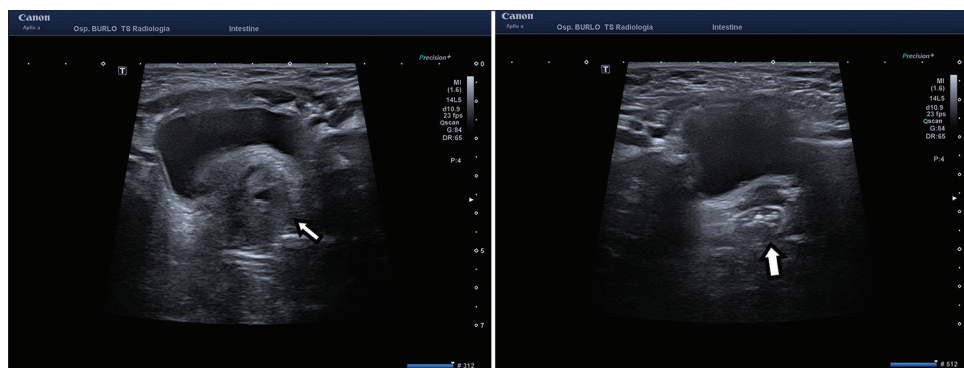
Ultrasound scans revealing the presence of a round hypoechoic mass located posterior to the bladder (left) and an oval-shaped hyperechoic structure located just on the left side of the bladder and showing no vascular supply (right)
